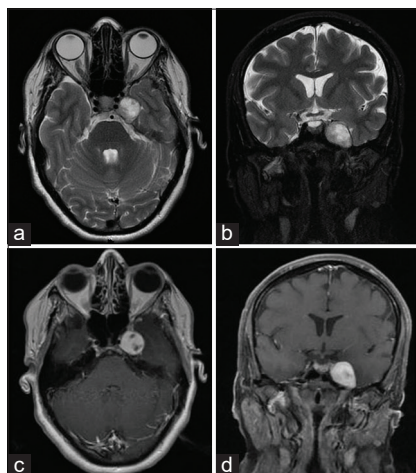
(a-d) Preoperative magnetic resonance imaging.
